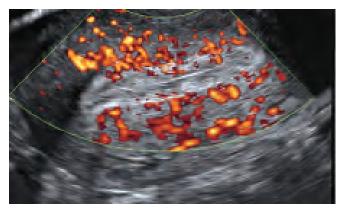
Endometrial vascularization in midcycle – the radial and spiral arteries. Power Doppler is used to visualize the low velocity flow in small vessels penetrating the endometrium. In this case the flow reaches the inner half of the endometrium (type III)
